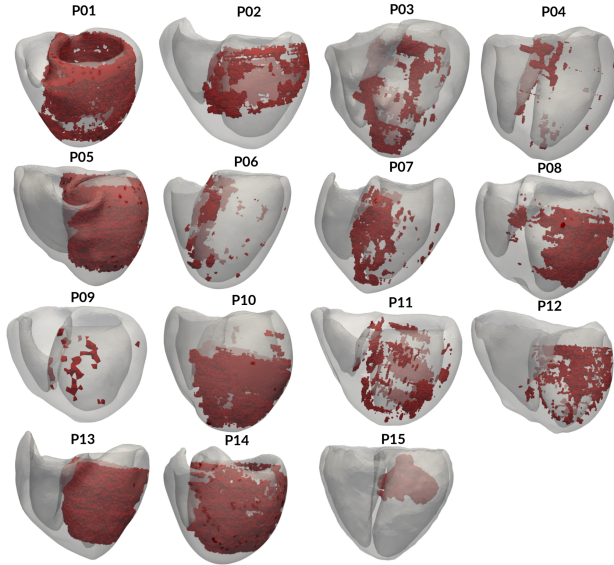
Personalized geometric models of ventricles from CT scans and fibrosis geometry from MRI scans. Ventricle and fibrosis geometries were manually merged.
